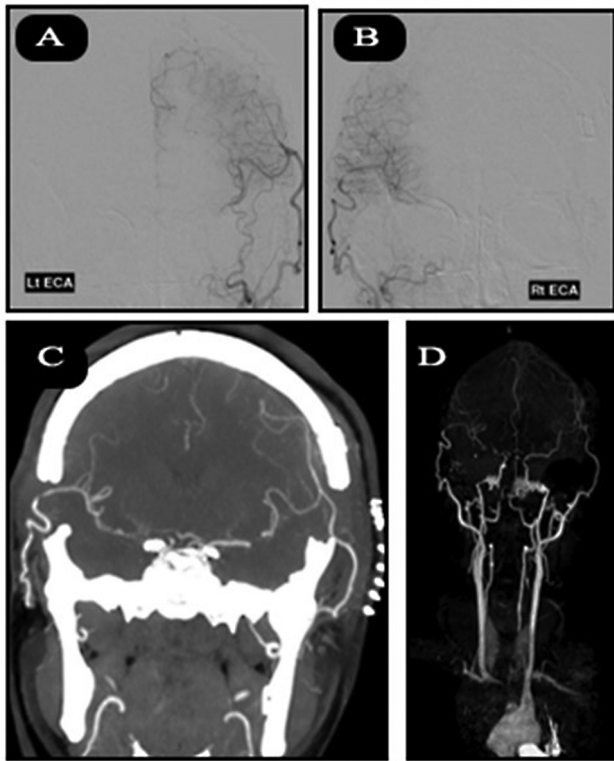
(A and B) Postoperative angiogram of external carotid artery demonstrating bilateral superficial temporal artery to middle cerebral artery (STA-MCA) bypass with moderate focal stenosis at the right (Rt) STA-MCA anastomosis. The left STA-MCA bypass appears patent. (C) No internal carotid artery (ICA) contribution from the radiotherapy or left ICA is seen. (D) Postoperative computed tomography and a volume rendering technique showing opacification of the left superficial temporal artery with anastomosis with the left MCA branches, well opacification of the Rt superficial temporal artery and Rt MCA branches, significant narrowing of the intracavernous and intracranial part bilateral ICAs.
